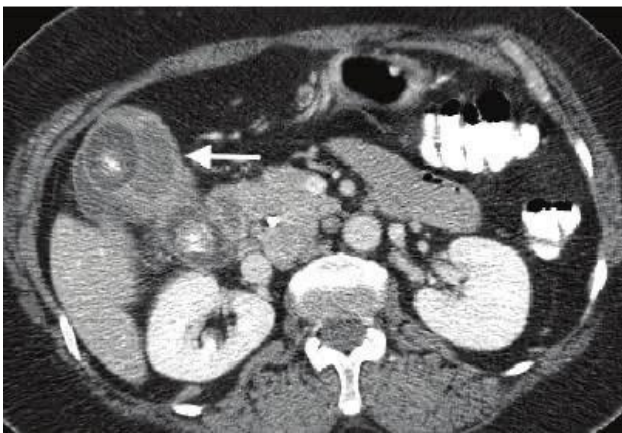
Triple-phase contrast-enhanced CT (CECT) of the abdomen showing a heterogeneously enhancing gallbladder mass.
